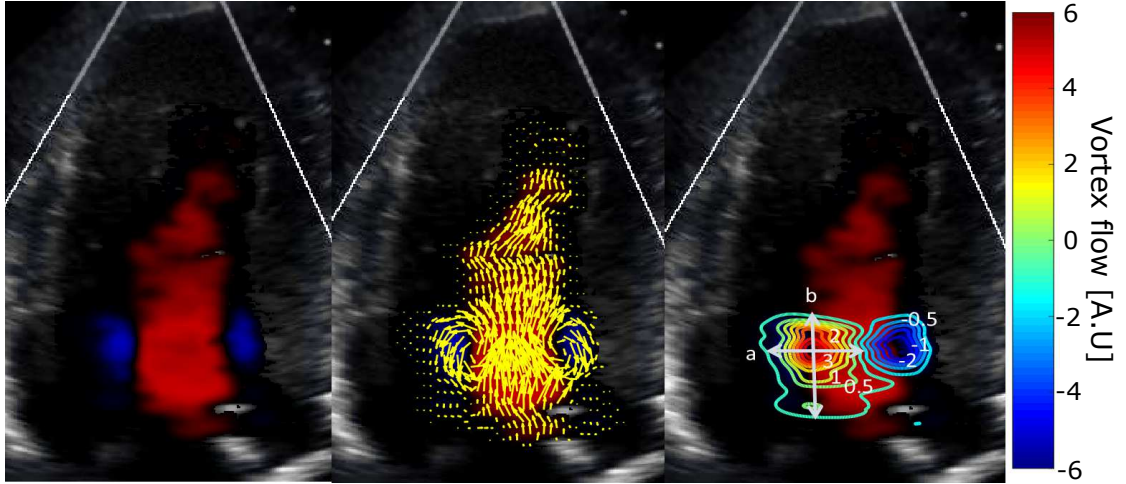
(Left to right) The conventional color Doppler, Two-dimensional (2D) flow velocity vectors, and the contour of the vortex area. Vortex cavity also describe vortex direction into a region with red (counterclockwise) and blue (clockwise).
